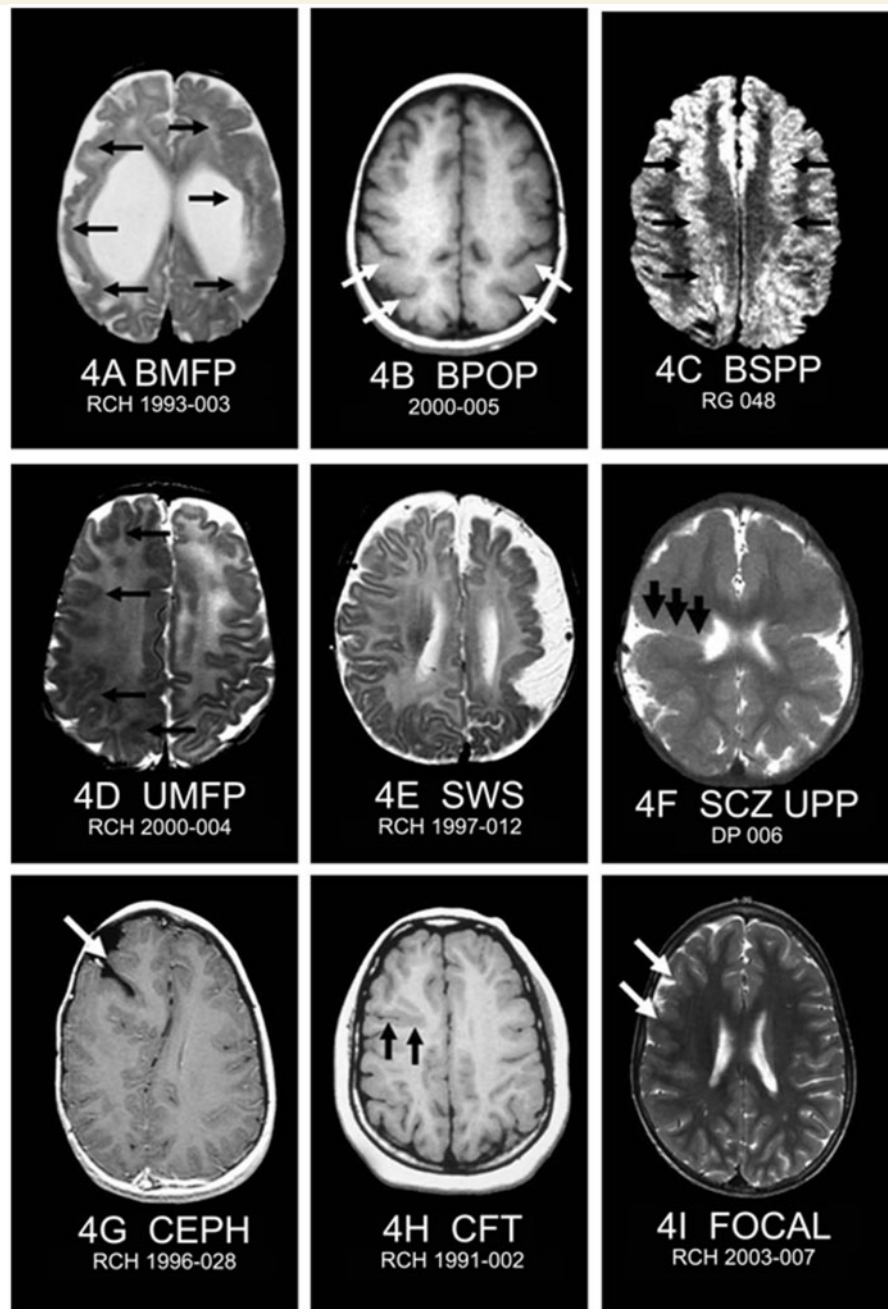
MRI features of atypical and rare patterns of polymicrogyria. All images are T₁, T₂ or fluid attenuated inversion recovery axial. (A) Bilateral multifocal polymicrogyria (BMFP) patchy throughout both hemispheres (arrows) with associated abnormal white matter signal and ventriculomegaly. (B) Bilateral parieto-occipital polymicrogyria (BPOP) with bilateral symmetric polymicrogyria in lateral parieto-occipital regions (arrows). (C) Bilateral superior parasagittal polymicrogyria (BSPP) with polymicrogyria lining abnormal deep symmetric parasagittal gyri extending from the frontal poles to the parietal lobes (arrows). (D) Unilateral multifocal polymicrogyria (UMFP) with multifocal polymicrogyria throughout the right hemisphere (arrows). This case was confirmed as polymicrogyria by pathology. (E) MRI from a child with Sturge–Weber syndrome who had epilepsy, a left-sided facial haemangioma and left eye glaucoma. The images show atrophy of the left hemisphere with extensive polymicrogyria. CT scanning showed cortical calcifications and contrast-enhanced imaging suggested pial angiomas typical of Sturge–Weber syndrome. (F) Unilateral closed-lip schizencephaly and contralateral perisylvian polymicrogyria (schizencephaly UPP). There is extensive polymicrogyria bilaterally, maximal along the Sylvian fissures. On both sides, there were deep clefts extending towards the lateral ventricles lined by polymicrogyria. On the right side, this cleft communicated with the lateral ventricle showing the ‘pia-ependymal seam’ typical of schizencephaly (arrows). The left-sided cleft did not communicate with the lateral ventricle. (G) Polymicrogyria associated with an encephalocoele (CEPH) showing a deep cleft (arrow) surrounded by irregular, thickened grey matter consistent with polymicrogyria underlying the site of a previously-repaired right frontal encephalocoele. (H) Polymicrogyria associated with a deep cleft (CFT) in the right mid-frontal lobe extending towards (but not communicating with) the lateral ventricle (arrows). This cleft is lined by irregular, thickened grey matter suggestive of polymicrogyria. (I) Focal polymicrogyria (FOCAL) with an irregular area of polymicrogyria over the right mid-frontal region (arrows).
